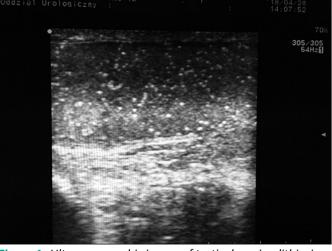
Ultrasonographic image of testicular microlithiasis (34-year-old man seen in emergency department for testicular pain).
